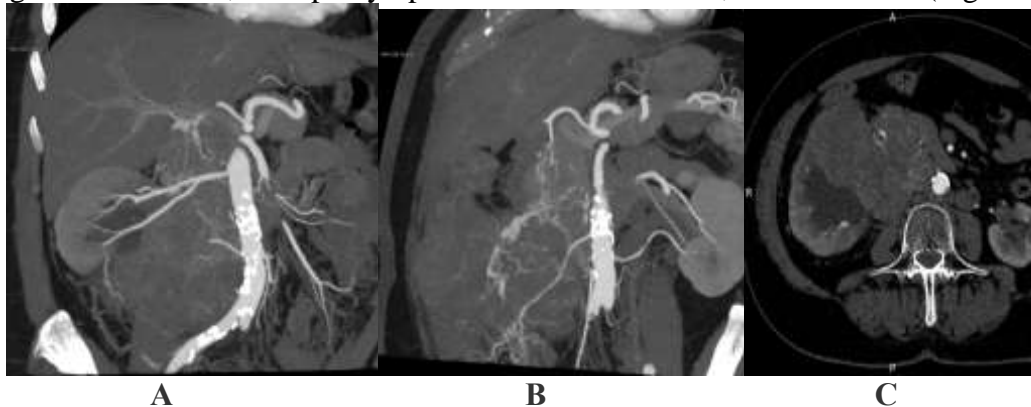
CT scan of the abdominal cavity with IV contrast in the arterial phase (A, B) in the portal phase (C):
